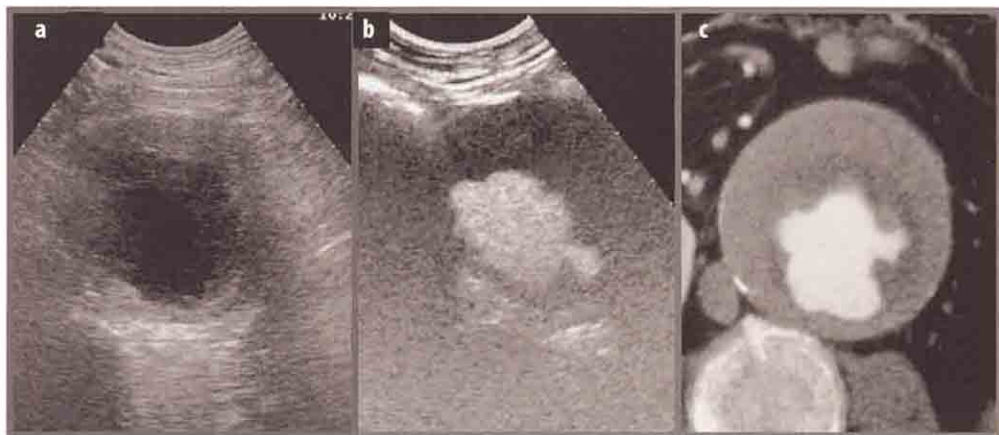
Abdominal aorta aneurysm.* a Transversal scan, B-mode. An abdominal aortic aneurysm with an inhomogeneous, hypoechoic, peripheral thrombus is detectable; a correct evaluation of the thrombus surface and therefore of the diameter of the residual lumen is prevented, because of its morphological appearance. b Transversal scan, CEUS. The aortic lumen is homogeneously enhanced by contrast agent, appearing hyperechoic; the peripheral thrombus inner surface is remarkably irregular. c Helical angio-CT corresponding scan. Contrast agent outlines the thrombus profile; in such a situation, the residual lumen is well depicted and so is the presence of large penetrating atheromasic ulcers
